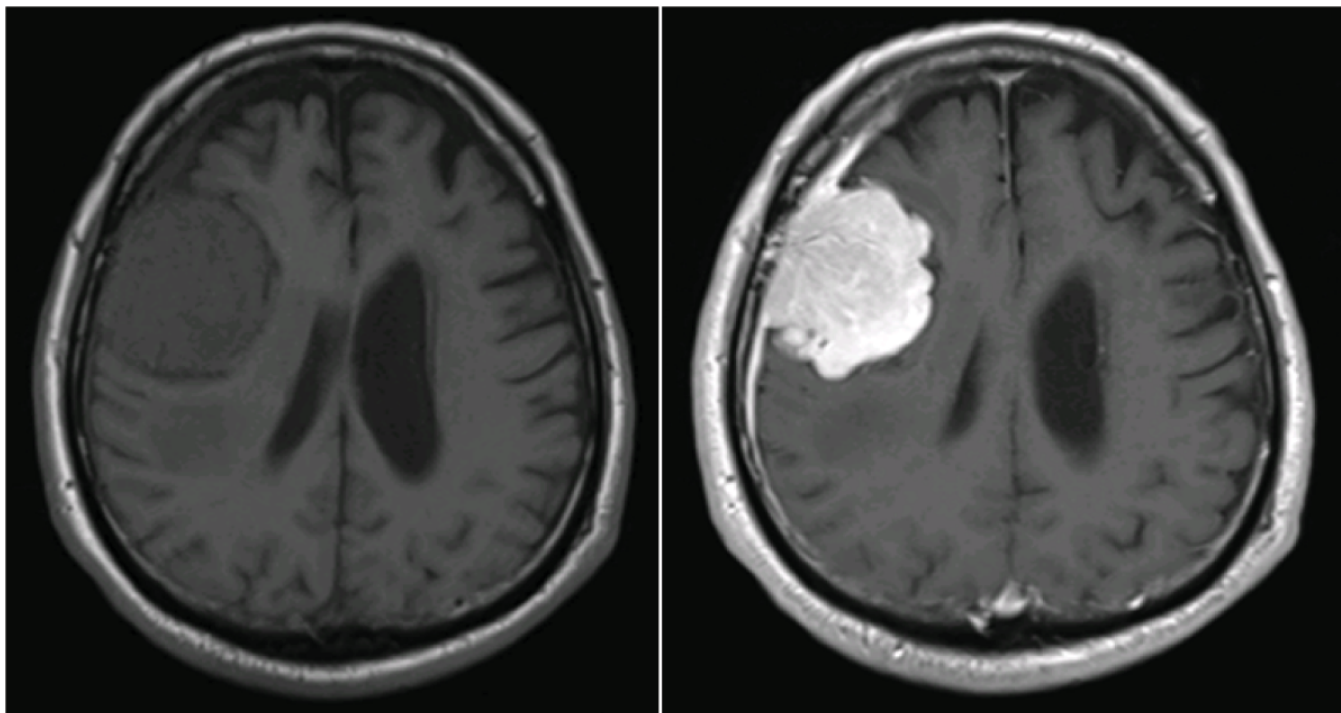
MRI brain axial sections T1 weighted images, with and without contrast, showing homogeneously enhancing, lobulated, extra-axial lesion in the right frontal area which is originating from the dura and is displacing the adjacent brain parenchyma. This is a convexity meningioma, suitable for ERAS protocol.
